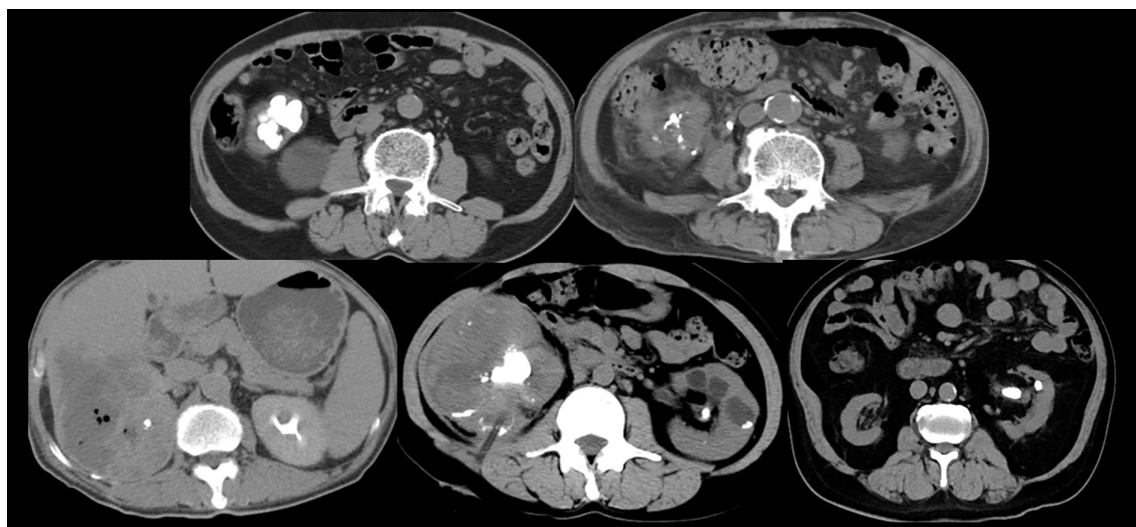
Preoperative computed tomography (CT) images of selected patients.
